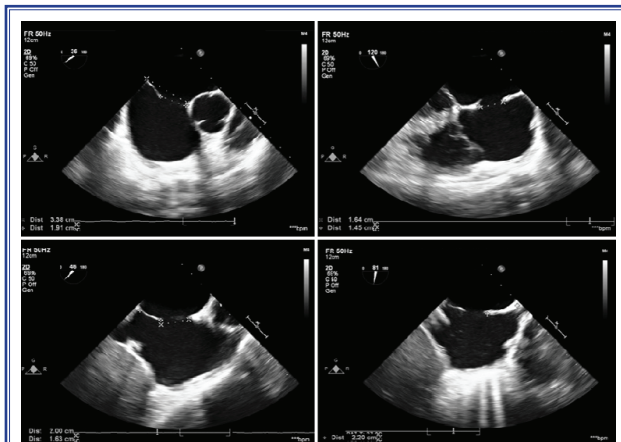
Transesophageal images of the atrial septal defect and rims.
